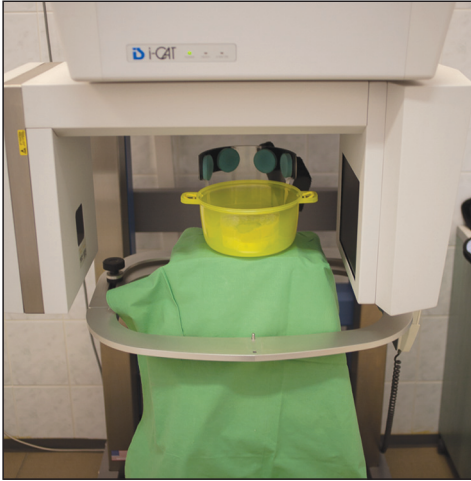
Preparing CBCT scan
